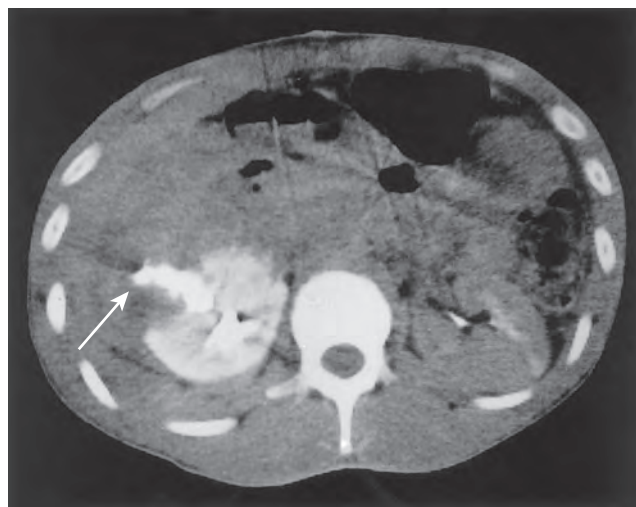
Computed tomography scan of a right renal stab wound (grade IV) (arrow), demonstrating extensive urinary extravasation and large retroperitoneal hematoma.
